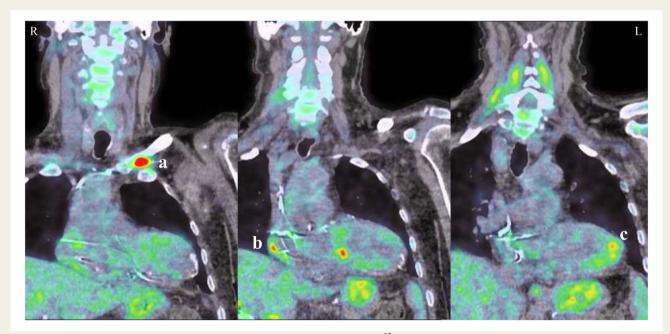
Positron emission tomography/computed tomography shows increased ¹⁸fluorodesoxyglucose uptake on the extracardiac (A: box) and intracardiac (B: right atrium; C: right ventricle apex) portions of the pacemaker. These coronal images are compatible with pocket infection and lead endocarditis. L, left; R, right.
